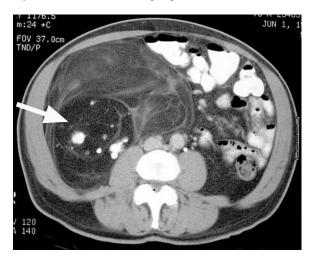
Liposarcoma. Contrast-enhanced axial CT shows large right retroperitoneal liposarcoma (arrow) composed predominantly of fat but also has areas of soft tissue density and calcific components.
